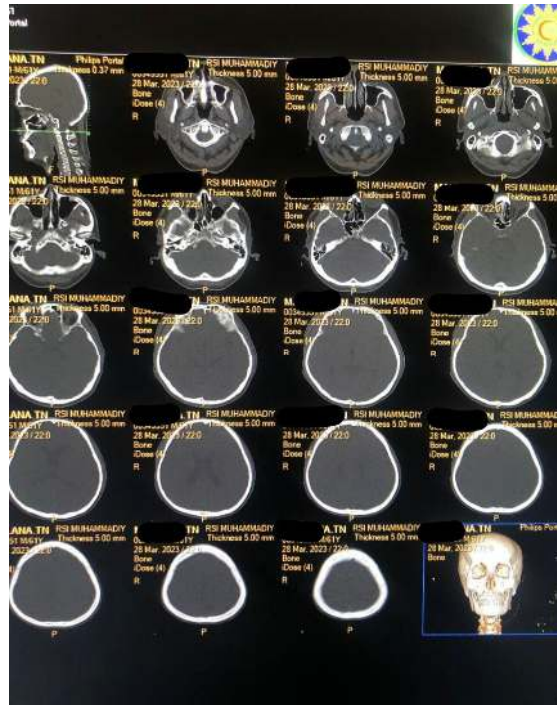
CT Scan Image of the Head Axial Brain Window
